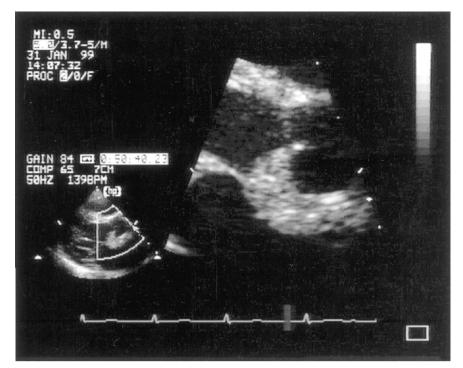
Detail from a parasternal long axis image from patient #2 demonstrating an abscess of the aortic root.
